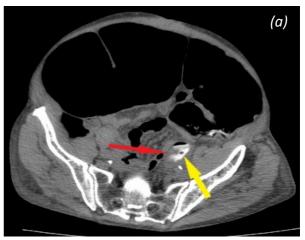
(a) Abdominopelvic CT scan showing suspected sigmoidal stenotic lesion of 3.5 cm diameter (red arrow) delineated by the contrast (yellow arrow) (b) Abdominopelvic CT scan showing the contrast in the descending colon (yellow arrow) bypassing the stenotic lesion and a prominently dilated colon
